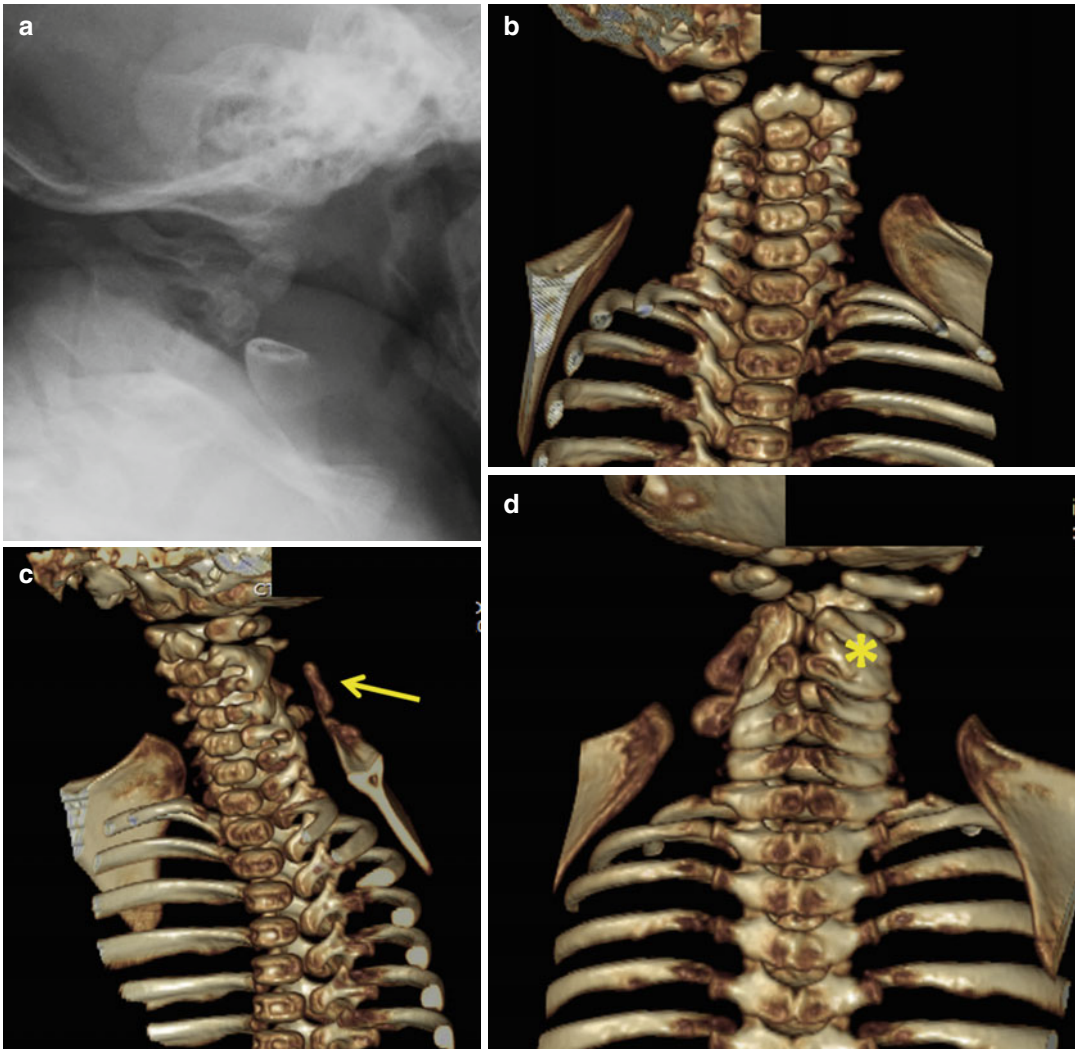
A 3-month-old girl with shoulder asymmetry. (a) The lateral cervical spine radiograph is difficult to interpret, but concerning because a cervical vertebral anomaly is present. A CT scan with three-dimensional reconstructions was performed. (b) The AP 3D CT scan reconstruction demonstrates no anterior vertebral anomalies, but the left scapula is hypoplastic, rotated, and higher than the right
